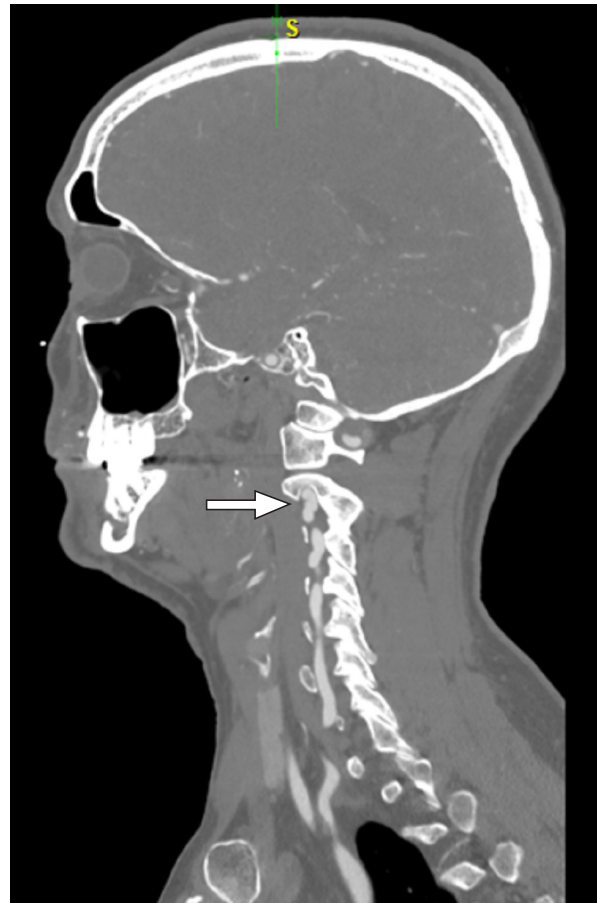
Computed tomographic angiogram (sagittal view) shows the beaded appearance of the mid-cervical right internal carotid artery (arrow) consistent with fibromuscular dysplasia extending over an approximately 2.5-cm segment.
